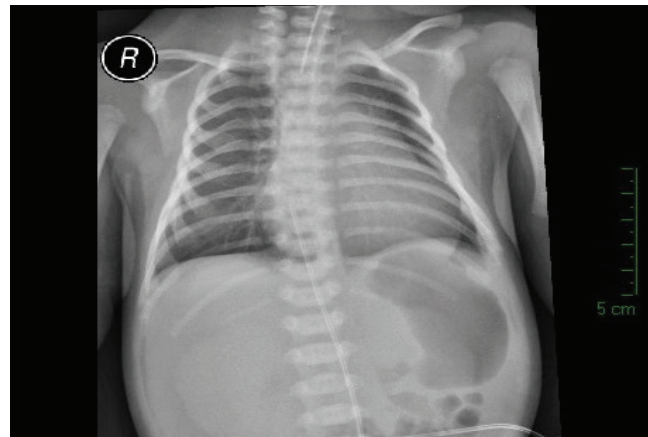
Direct roentgenogram showing the tip of the umbilical venous catheter (UVC) located in the right atrium
